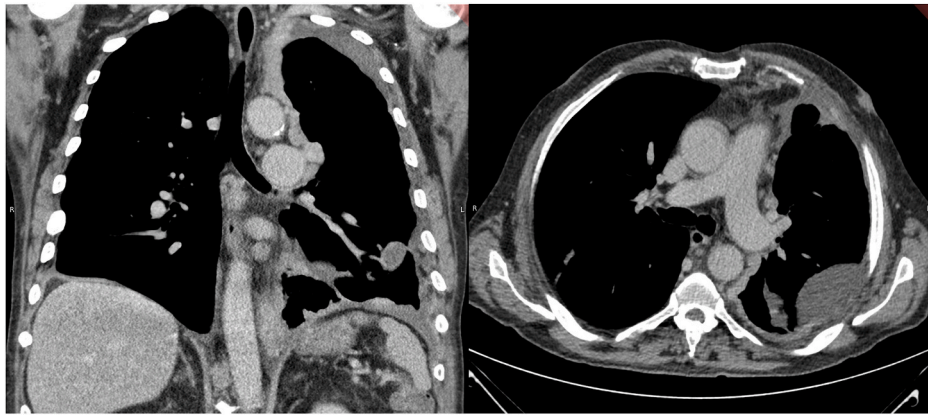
Contrast enhanced chest CT showing left-sided pleural thickening without contrast-enhancement and left-sided pleural effusion in pockets.
